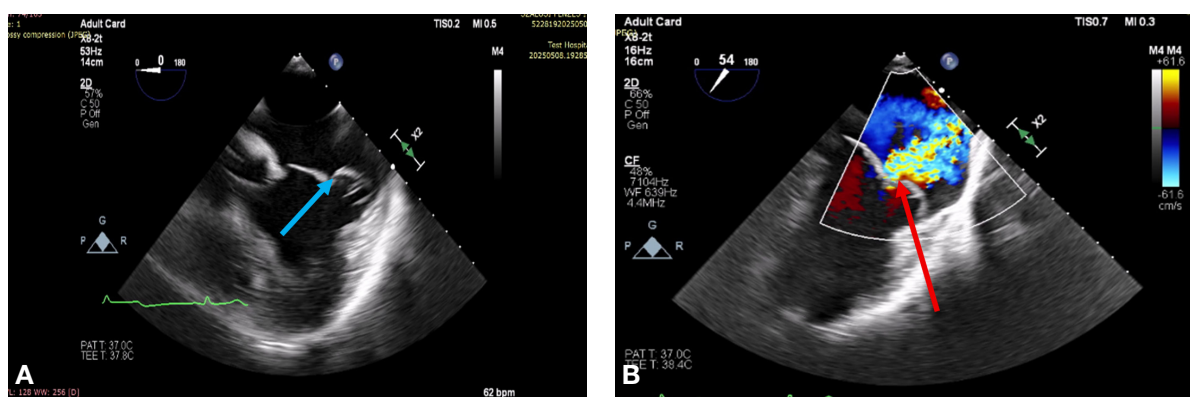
A - Preoperative transesophageal echocardiography showing a myxomatous mitral valve with bileaflet prolapse and morphological features compatible with Barlow disease. B - Preoperative transesophageal echocardiography with color Doppler showing severe mitral regurgitation.
